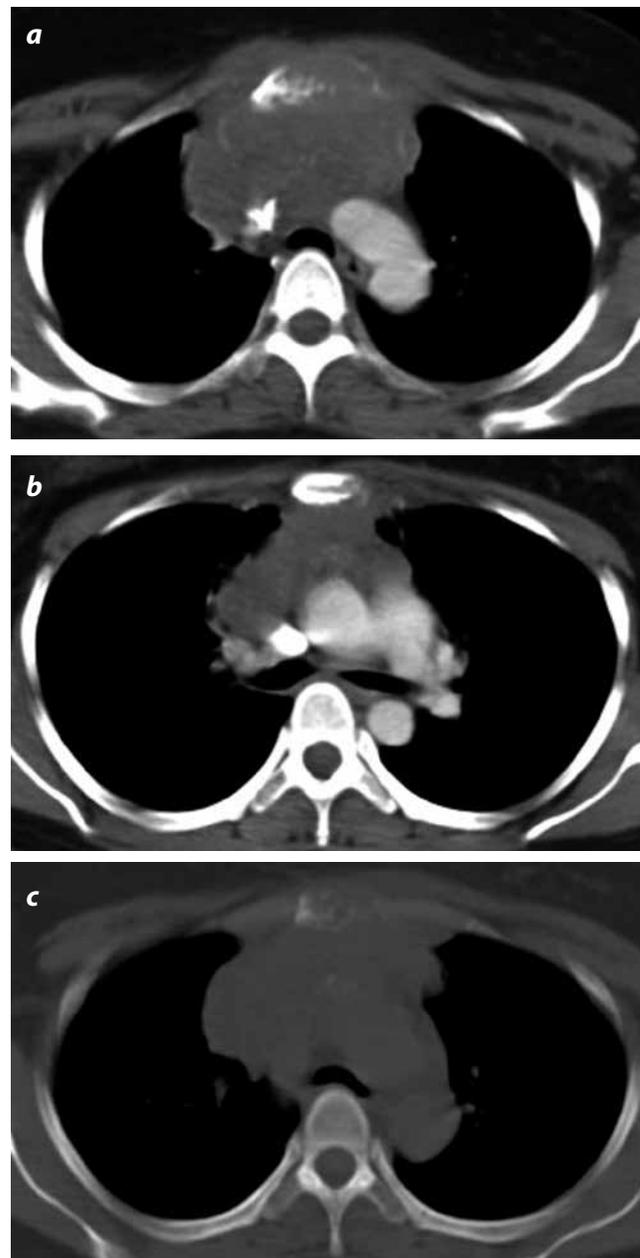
a and b). Thorax CT with endovenous contrast medium in window of soft tissue, c) bone. Lobulated contour mass with soft tissue density and scarce enhancement of the contrast medium, localized in the anterior mediastinum and producing compressive effect over the superior cava vein, decrease in the AP diameter of the trachea and infiltration to the sternum and the thoracic wall.
